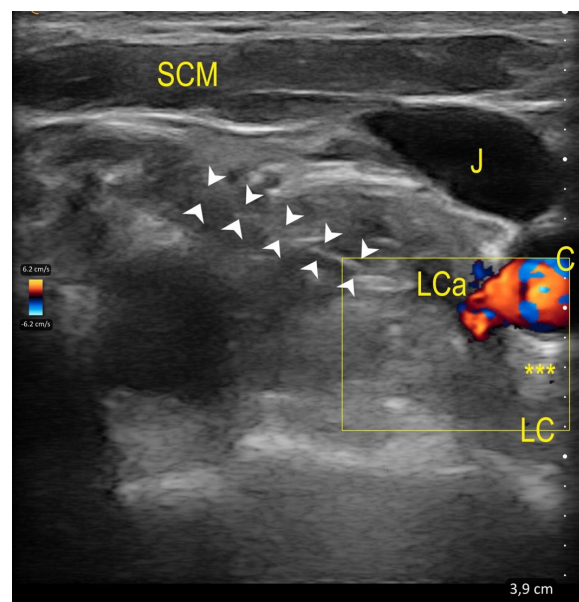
US-guided SGB block. A lateral, posterior-to-anterior, transverse approach was used, with needle inserted in-plane to the probe with color flow Doppler to address vasculatures and aid in hydrolocalization. C: carotid artery; J: jugular vein; SCM: sternocleidomastoid muscle; LCa: longus capitis muscle; LC: longus colli muscle; Arrowheads: penetrating needle; *: prevertebral fascia and target for SGB.
